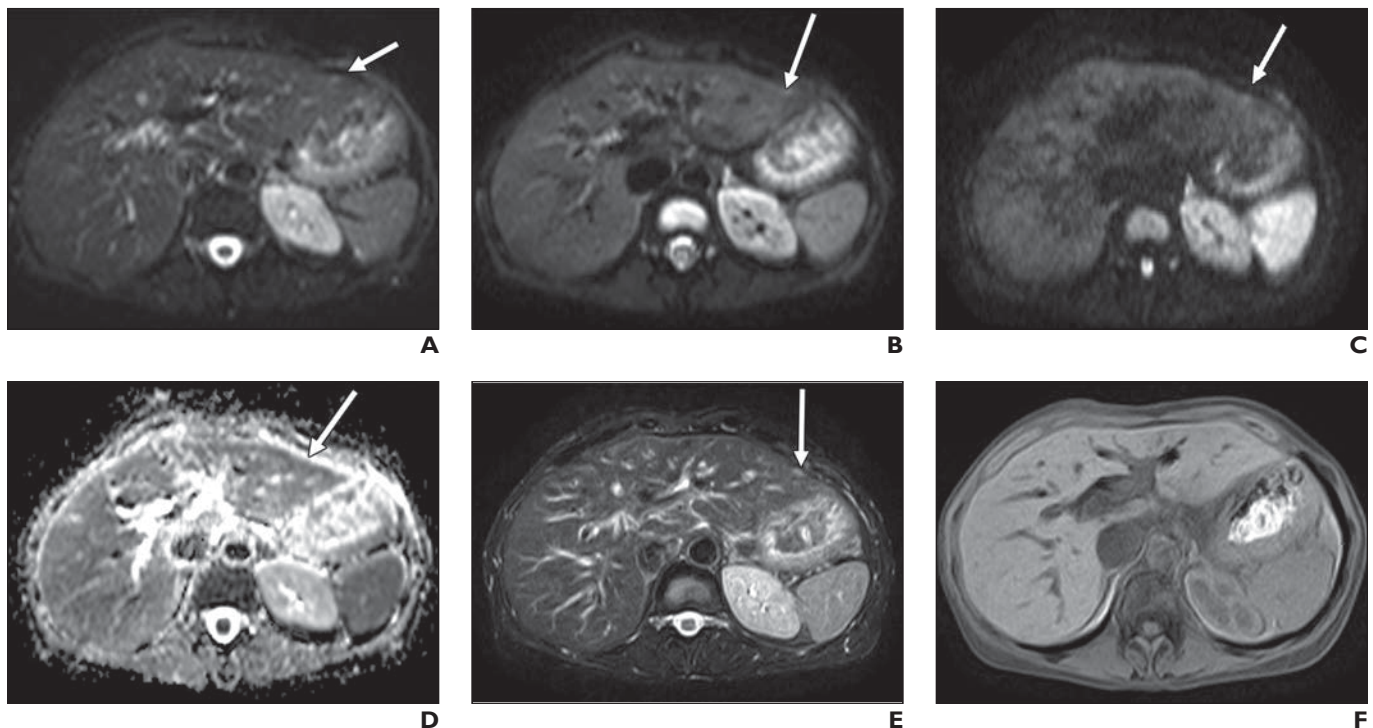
45-year-old woman with potentially resectable pancreatic adenocarcinoma undergoing preoperative imaging. Example of hepatic lesion undetectable at CT and false-positive MRI finding. Lesion was not seen at surgery. Five years after surgery patient was alive without left lobe liver metastasis or peritoneal nodule in this location.
